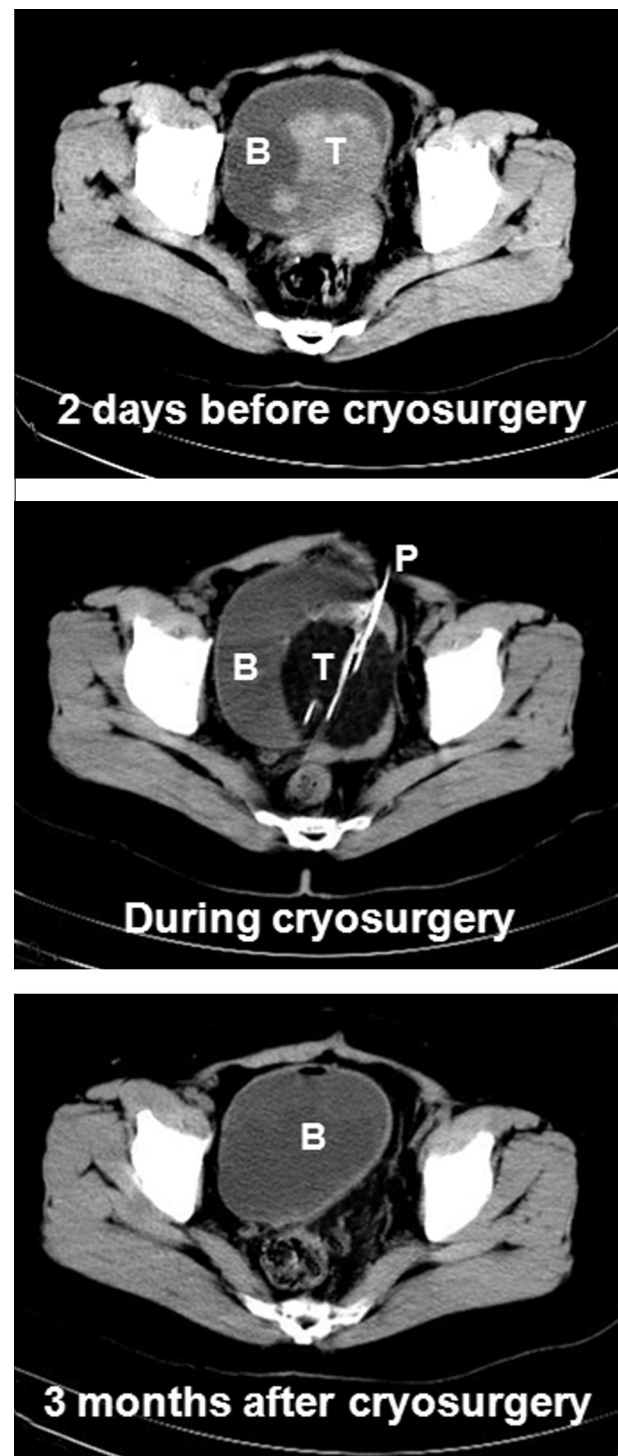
CT images of a patient with cancer in the right wall of the bladder. Two days before cryosurgery, the tumor (T) occupied more than half of the bladder (B). During cryosurgery with three probes (P), the ice ball grew gradually, surrounded the tumor and formed a low density area. Three months after cryosurgery, the structure of the bladder wall remained intact and tumor inside and outside the bladder had disappeared.
